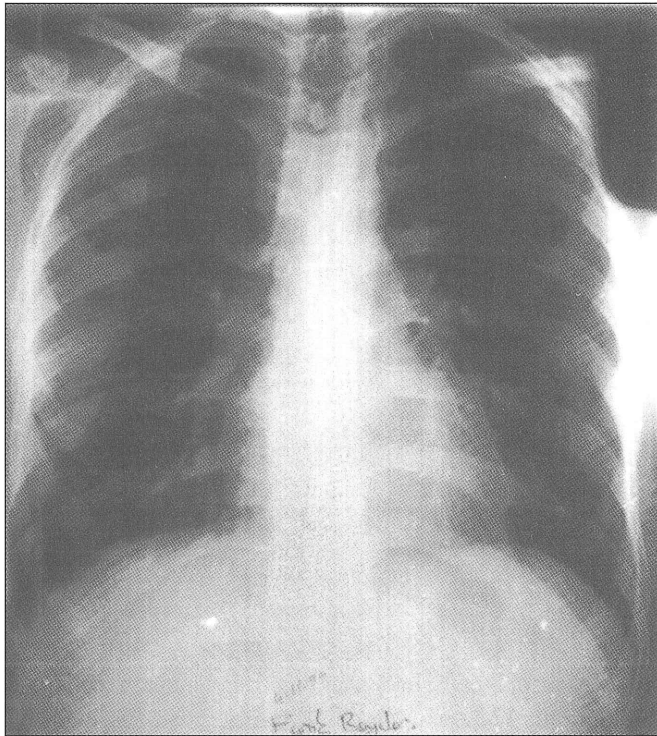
Control chest x-ray of the second case.
